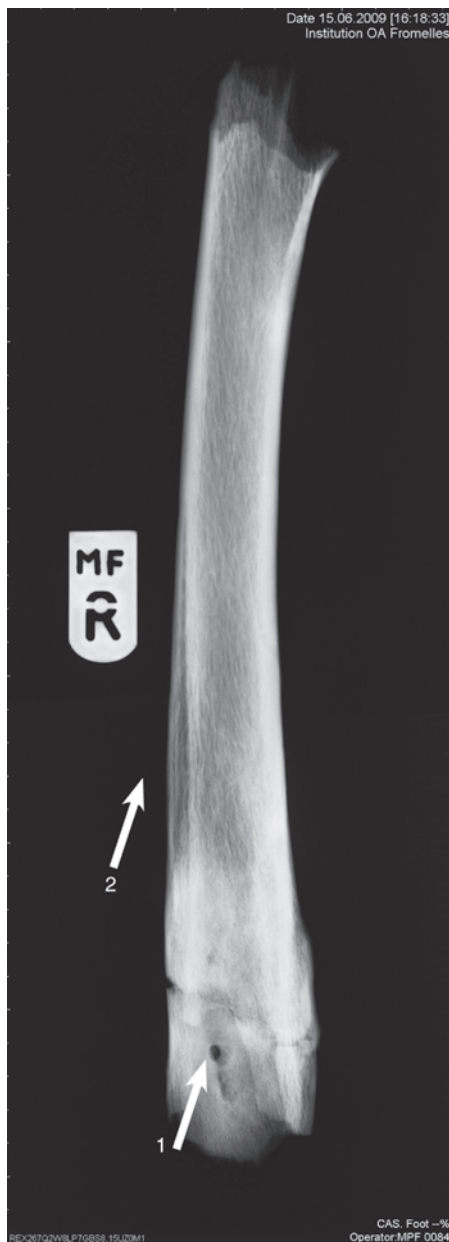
Radiograph showing cloaca (arrowed number 1) and involucrum (arrow number 2) (0268B)
